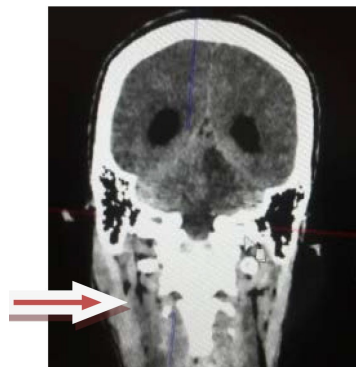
Coronal CT scan showing thrombosis of the right internal jugular vein.
